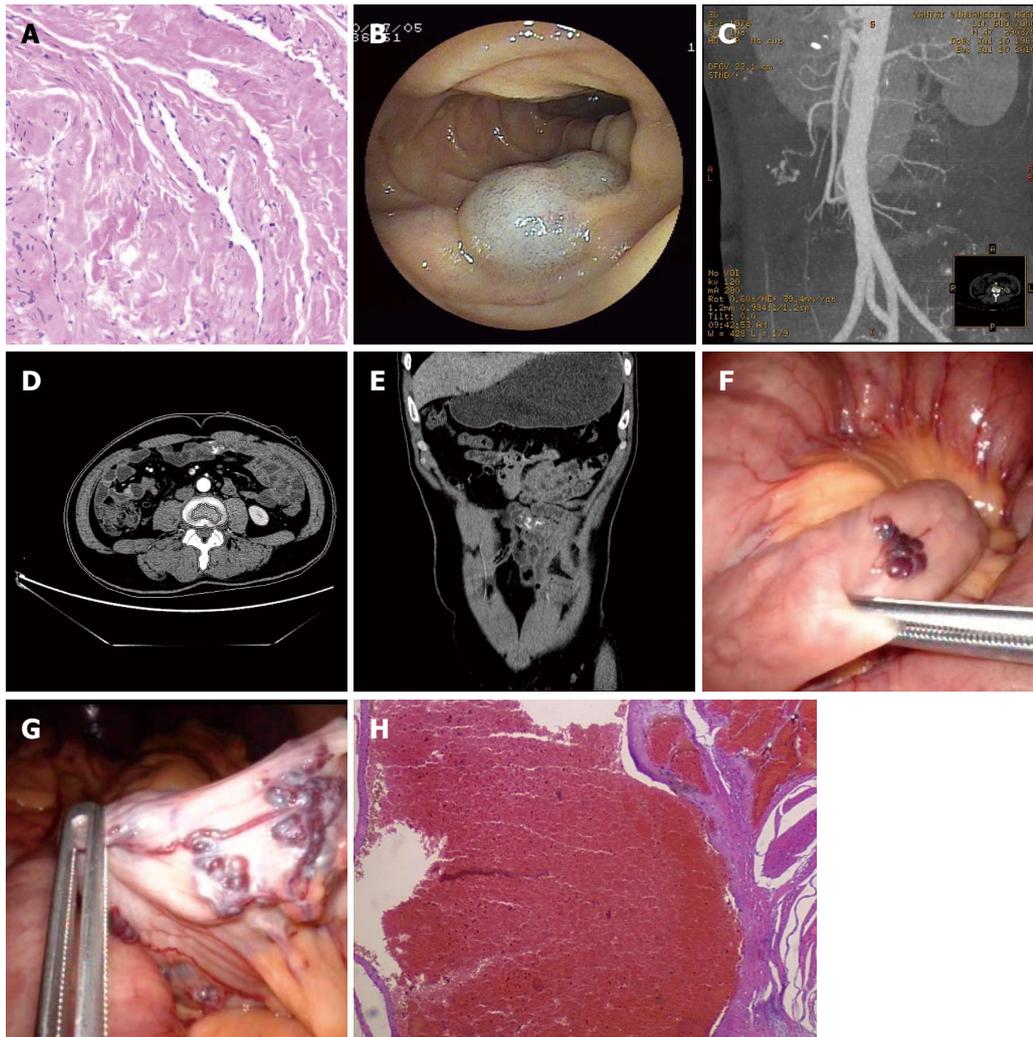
Skin, enteroscopy, abdominal vascular enhanced computed tomography, laparoscopy and pathological findings of the patient. A: Pathological analysis showed cavernous angioma on the right knee ($\times 400$); B: Angioma was indicated by oral approach enteroscopy; C: Arterio-venous malformation at the branch of the superior mesenteric artery was shown by abdominal vascular enhanced computed tomography (CT); D: Contrast media remained in the arterio-venous malformation, as shown by abdominal vascular enhanced CT at the cross section; E: Contrast media remained in the arterio-venous malformation, as shown by abdominal vascular enhanced CT in a reconstruction of a coronal view; F: A small intestinal angioma was detected by a laparoscopic approach; the tissue in this image corresponds to B; G: Arterio-venous malformation was found by a laparoscopic approach; the tissue in this image corresponds to C-E; H: By pathological examination, the resected small intestinal arterio-venous malformation was shown to have a vessel wall that was irregular, distorted and dilated ($\times 400$).
